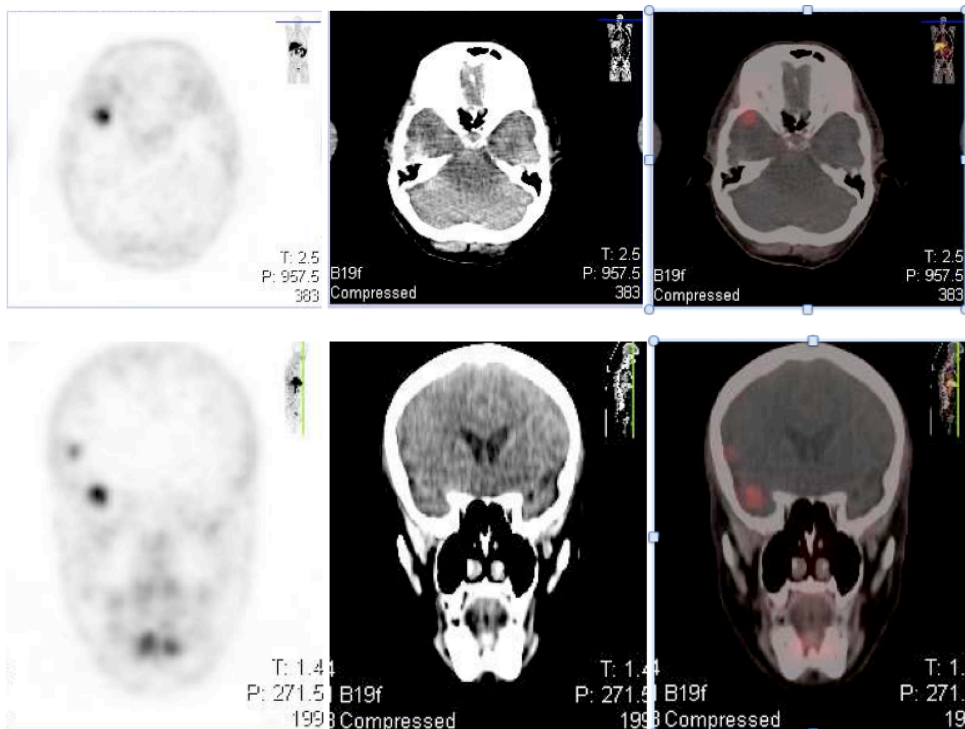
F-18-Choline allows for better detection of tuberculous brain involvement compared to F-18-FDG.
